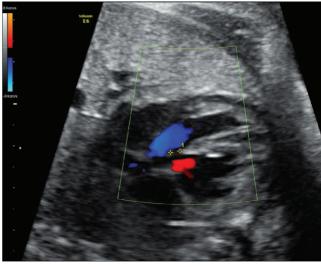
Color Doppler images of inlet perimembranous ventricular septal defect, situated in lower portion of perimembranous septum. Flow across defect (red) clearly presents a different direction from that of aorta (blue), which comes entirely from left ventricle.
